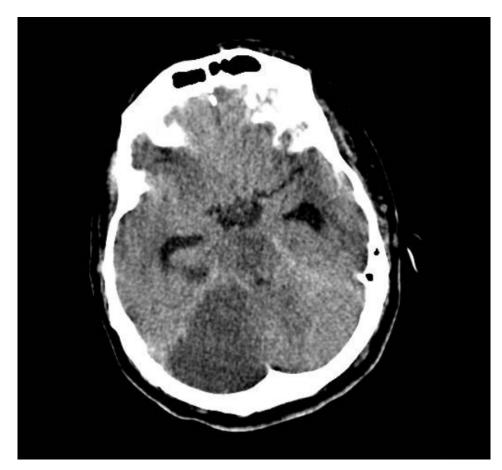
Brain CT scan on the fourth day of admission showing edema and mass effects impacting the fourth ventricle due to the swelling and infarct edema.
